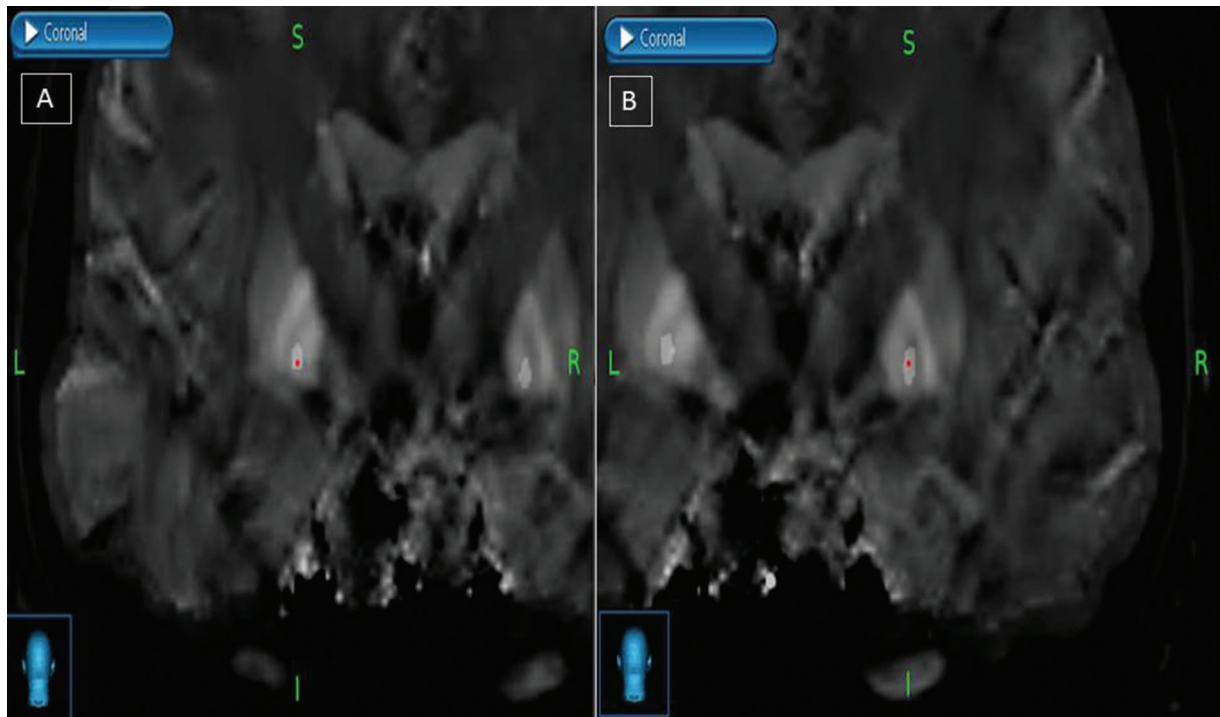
Bilateral DBS electrode position. Preoperative magnetic resonance imaging quantitative susceptibility mapping of coronal sequences showing the co-registered postoperative computed tomography location of the centroid (red dot) of the left (A) and right (B) electrodes in the globus pallidus internus.
